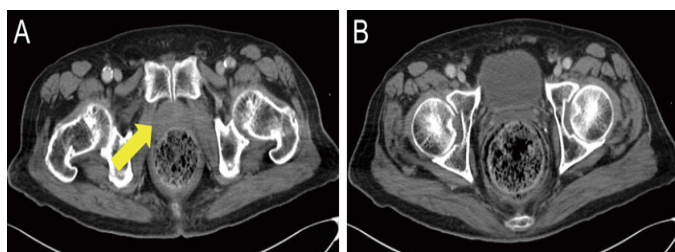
Contrast-enhanced CT performed on day 1 showing (A) a slightly lower-density area visible on the right side of the prostate (arrow) with no contrast effects seen in the surrounding region and (B) a significant quantity of fecal matter noted in the patient’s rectum from K Susuki et al.
